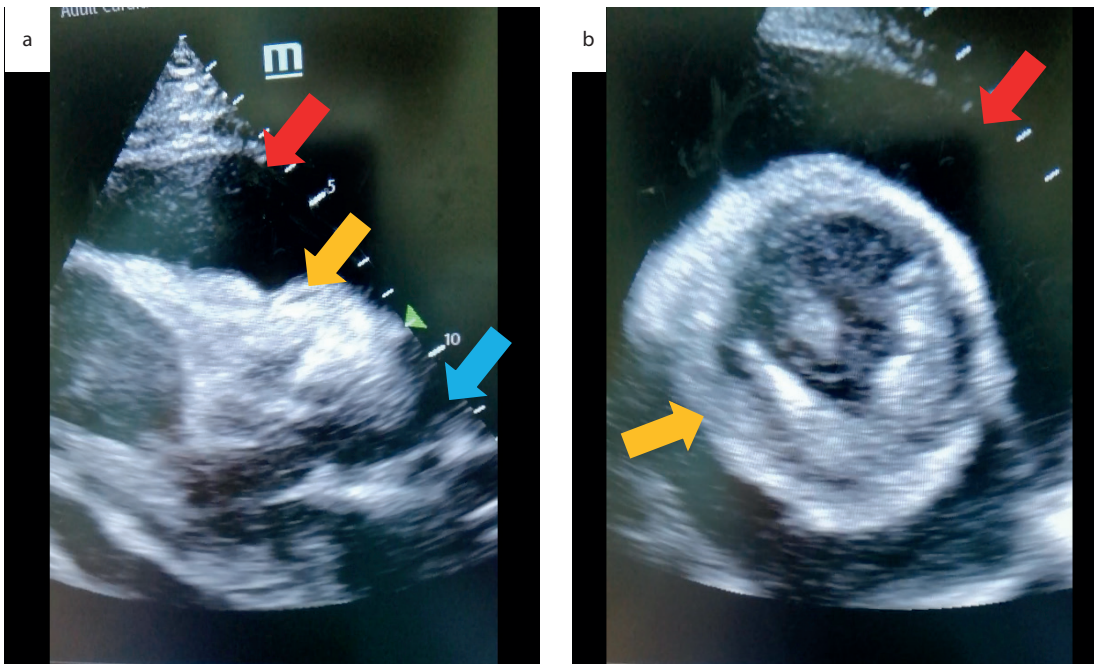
Bedside cardiac echocardiography: (a) Parasternal long-axis view and (b) Parasternal short-axis view during diastole phase identified an aortic root measuring 3.3cm with no intimal flap seen (blue arrow), massive pericardial effusion (maximum thickness of 3cm) (red arrow), and right ventricular collapse (orange arrow).
